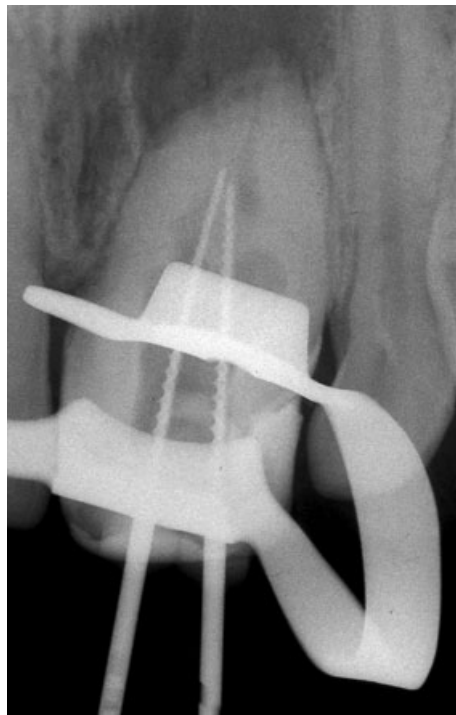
Radiographic working length determination.
